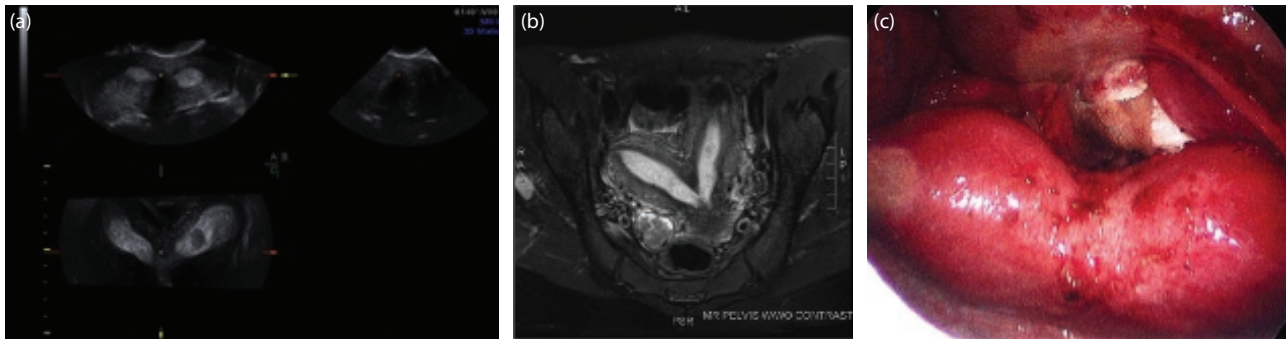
(a) Three-dimensional view of bicornuate uterus. (b) Magnetic resonance imaging of bicornuate uterus. (c) Laparoscopy of bicornuate uterus.
